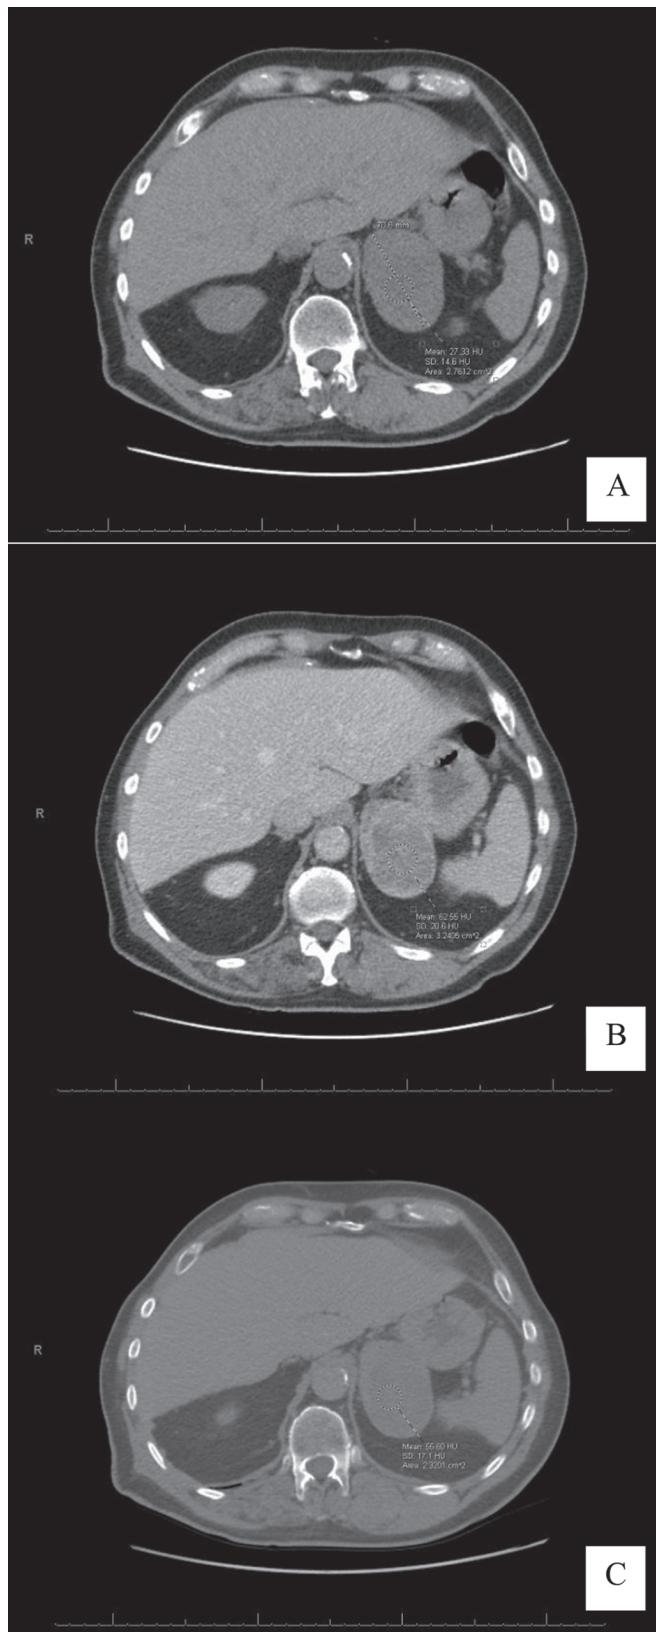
Three-phase adrenal mass protocol CT scan. A, Unenhanced CT scan (time zero). Left adrenal measures at 27 Hounsfield units. B, Contrast-enhanced CT scan (60-90 seconds). Left adrenal measures at 63 Hounsfield units. C, Delayed CT scan (10-15 minutes). Left adrenal measures at 57 Hounsfield units. Absolute washout = 16.7%; relative washout = 9.5%.
